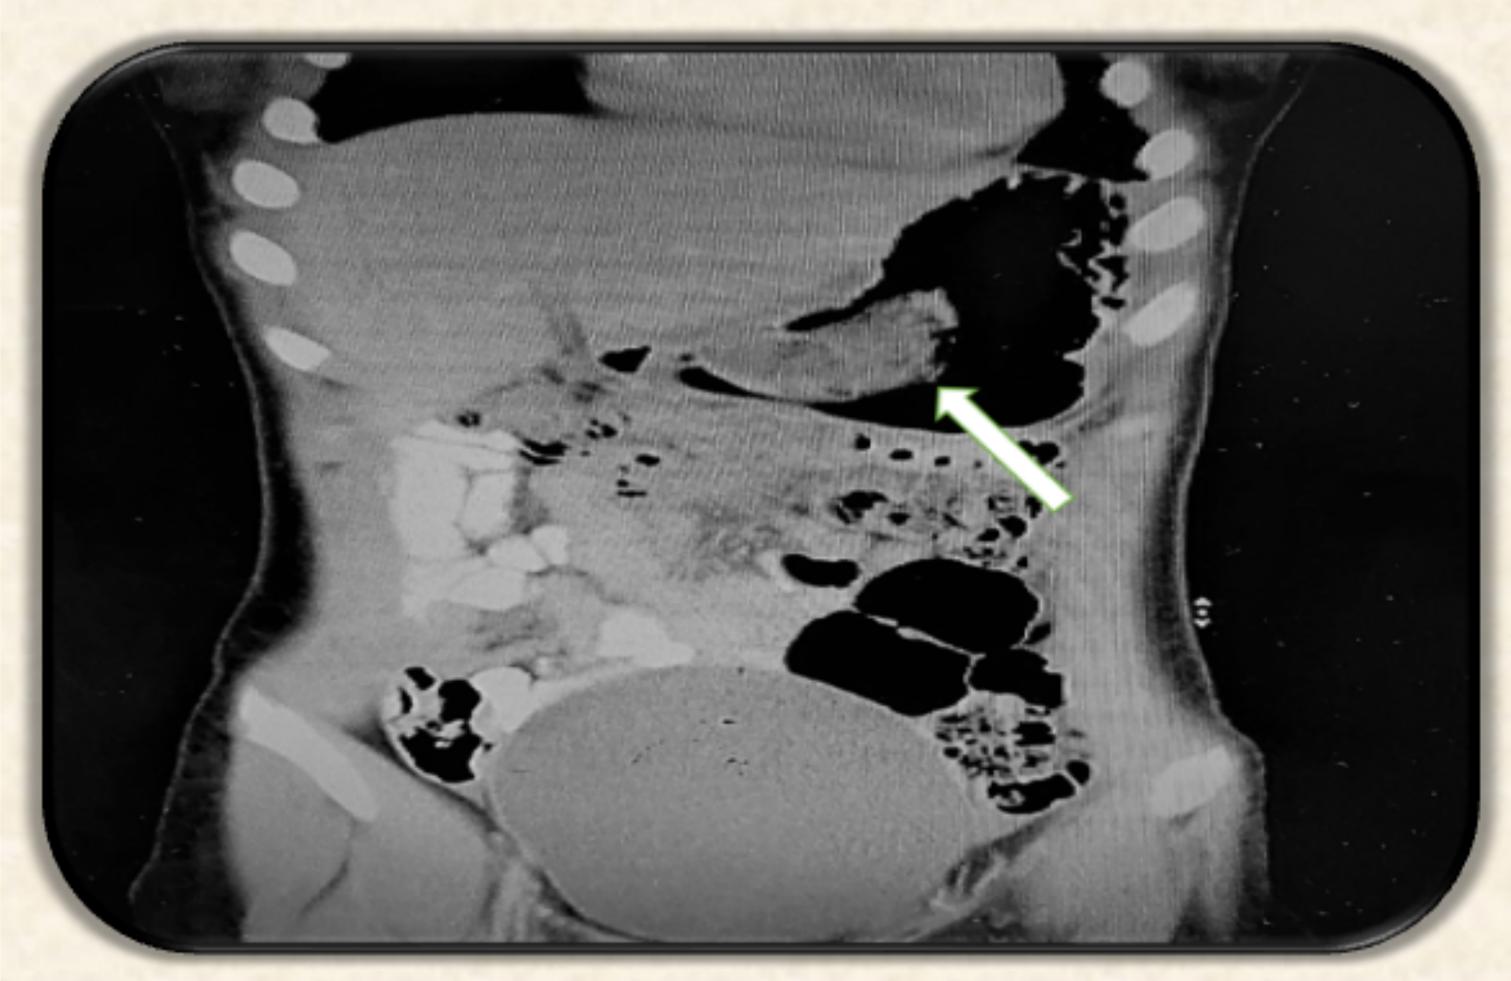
CT-scan abdomen showing the bezoar at the pylorus
